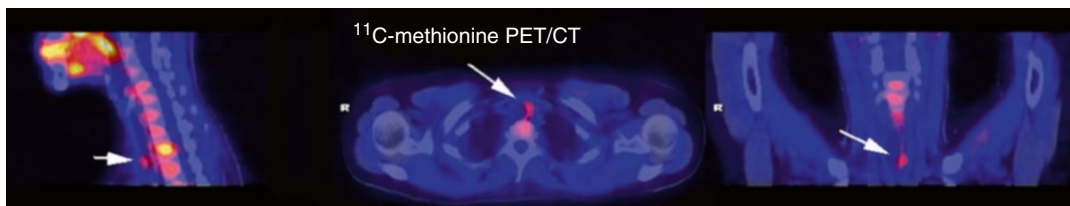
Regional ^{11}C -methionine PET/CT of a recurrent medullary thyroid cancer (*arrows*) in a patient presented with elevated Calcitonin after thyroidectomy
